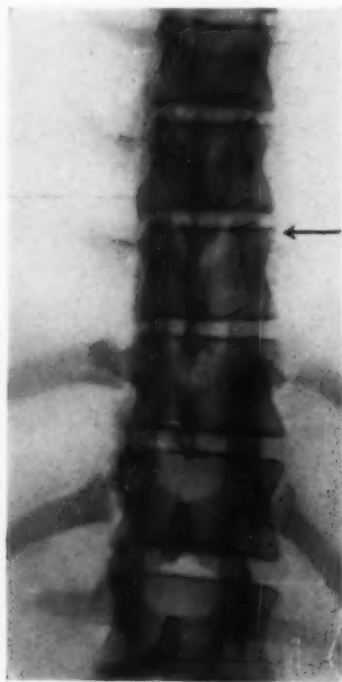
Photograph of X-ray of spine (not retouched) to show localization of the lower margin of a spinal cord tumor by the air shadow. Air can be seen distinctly as a column through all the vertebrae below the arrow. The shadow as here reproduced is necessarily much less sharp than in the original. The tumor was an extradural sarcoma. (Case VII.)
